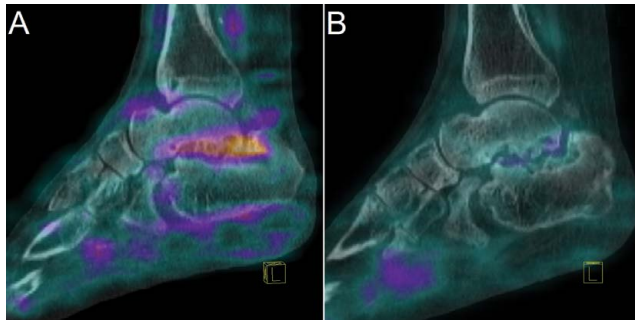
Initial SPECT/CT of the right foot shows intensive accumulation of radiolabeled white blood cells in the subtalar joint (A). Six months after radionuclide synovectomy there is only physiological distribution of radiolabeled white blood cells in the joints of right foot (B)
